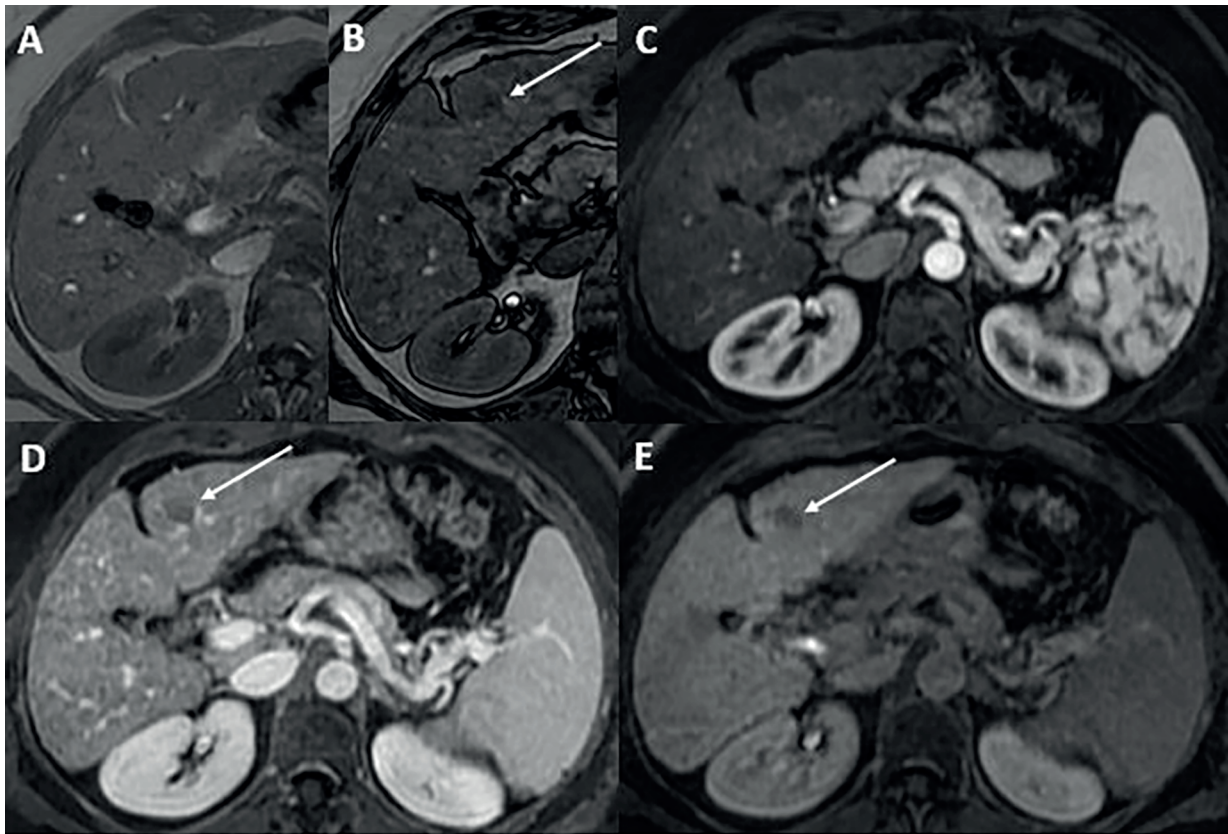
MR images show a liver observation measuring 19 mm in segment IV categorized as LR-3 according to LI-RADS v2018 algorithm and upgraded to LR-4 after applying ancillary features. (A) Axial T2-weighted; (B) Axial T1-weighted with fat saturation; (C) Diffusion weighted imaging; (D) Post-contrast arterial phase; (E) Post-contrast delayed phase; (F) Hepatobiliary phase. The lesion is mildly hyperintense on the T2-weighted image (arrow in A), isointense to the liver on the pre-contrast T1-weighted image (B) with no evidence of restricted diffusion (C). At post-contrast imaging, the observation shows no arterial phase hyperenhancement (D), presents nonperipheral “washout” (E) and is hypointense on hepatobiliary phase (F). In this case, ancillary features (mild T2 hyperintensity and hypointensity on hepatobiliary phase), led to category upgrade to LR-4. HGDN was confirmed with pathologic analysis after biopsy.
